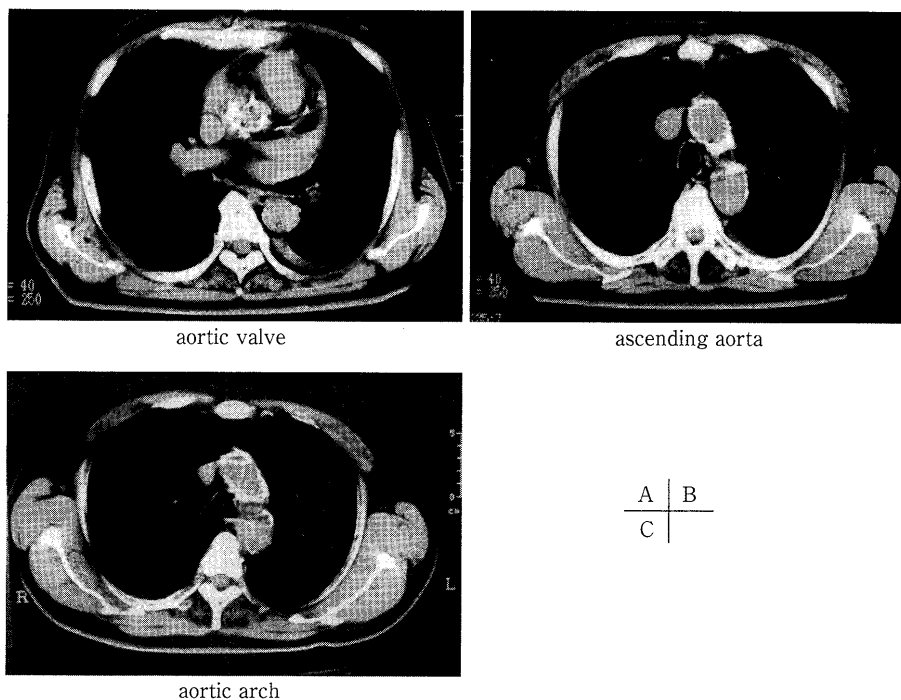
Computed tomography shows severe calcification of the aortic valve (A), entire ascending aorta (B), and aortic arch (C).
